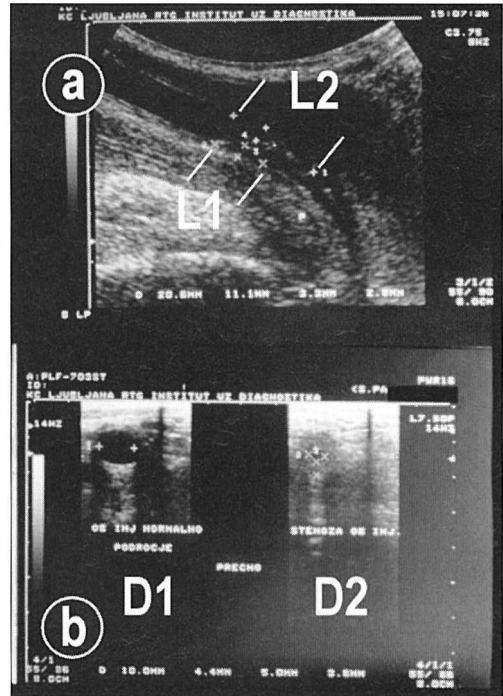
Sonographic urethrography-measurements of strictures; a) Longitudinal scan, b) Transverse scans. L2-the whole length, L1-the length of a tight stricture, D1-normal diameter, D2-reduced diameter.
